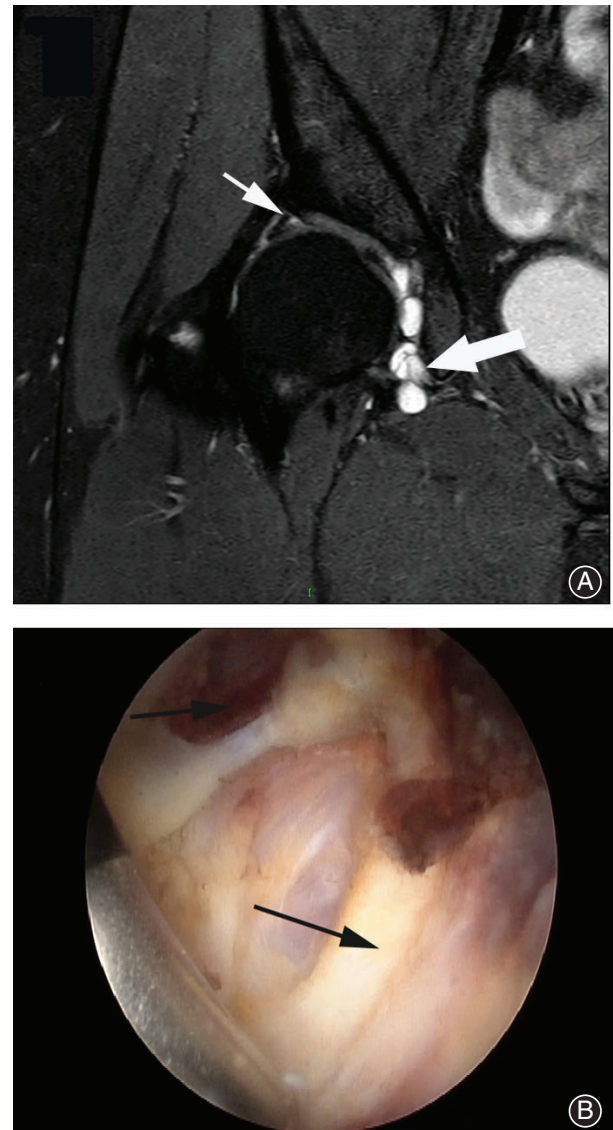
Forty-five-year-old woman presented with a 2-year history of right hip pain with limitation of hip flexion and internal rotation. (A) MRI showed labral tear (thin arrow) combine with the cystic changes (wide arrow). (B) Arthroscopic view of the cystic changes (short arrow) in the iliopsoas tendon (long arrow).
